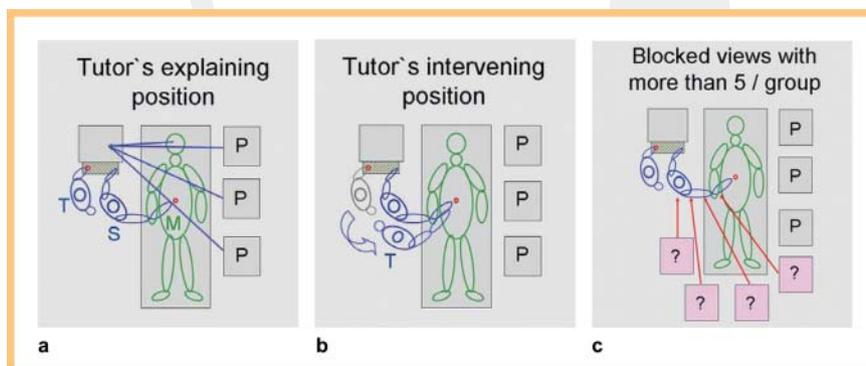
Optimized position of the tutor (T) in practical exercises: The left hand operates the unit and trackball for explanations on the ultrasound image (a). Taking one step forward allows the right hand to help the current sonographer (S) correct the transducer position (b). This largely avoids blocking of the line of sight of the remaining participants (P). If more than 3 to 4 passive participants are present, their view of the monitor would be impaired by the sonographer's arm and shoulder (c). Adequate rotation and tilt of the monitor is also important for the participant acting as the ultrasound examination subject (M).
